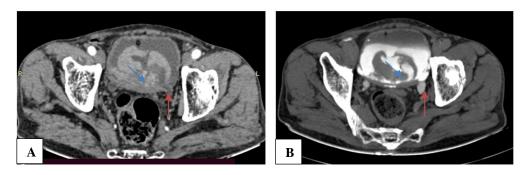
A) On axial nephrogenic phase of CT urography in bladder malignancy (blue arrow) involving left vesicoureteric junction (red arrow); (B) on axial excretory phase of CT urography in bladder malignancy involving left vesicoureteric junction showing left lower ureteral dilation (red arrow).
